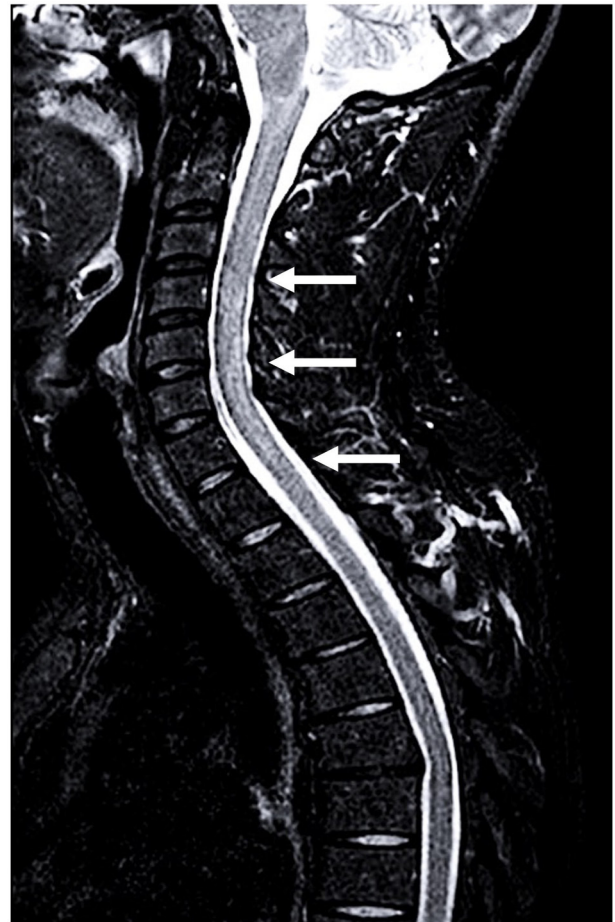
Spine magnetic resonance imaging. Hyperintense cervical cord lesions (arrows) in short-TI inversion recovery sagittal sequences.
